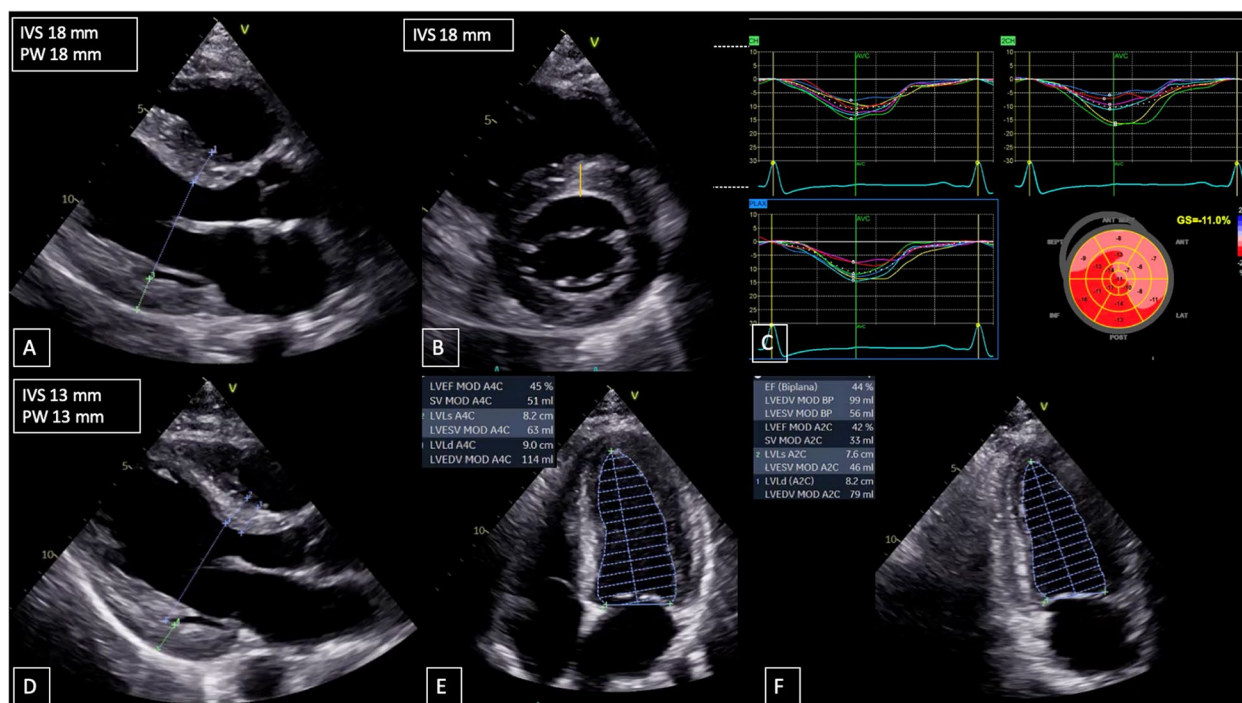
Echocardiogram at the admission showed concentric left ventricle hypertrophy (A, B), reduced ejection fraction (EF 22%) and reduced [GLS – 11%] (C). At discharge (15 days later), the echocardiogram showed reduced wall thickness (D) with mild improvement in LV function (EF 45%) using Simpson’s biplane method (E, F)
